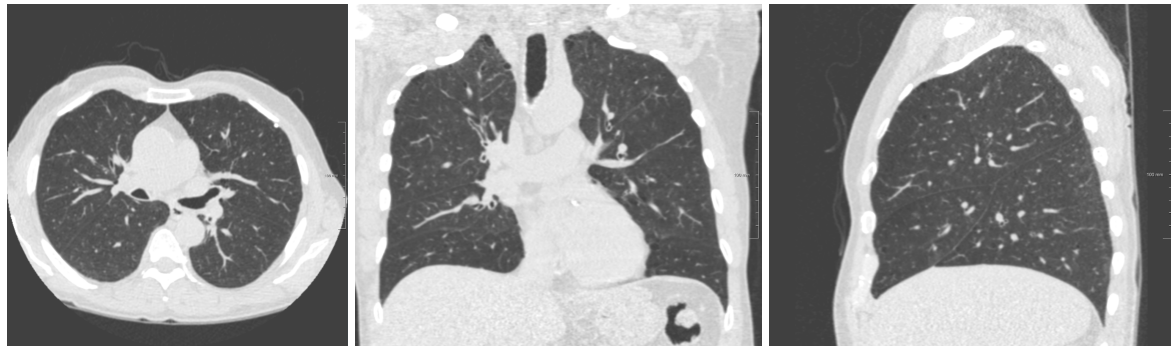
Three orthogonal images of a chest CT scan. Left: axial slice, middle: coronal slice, right: sagittal slice.
